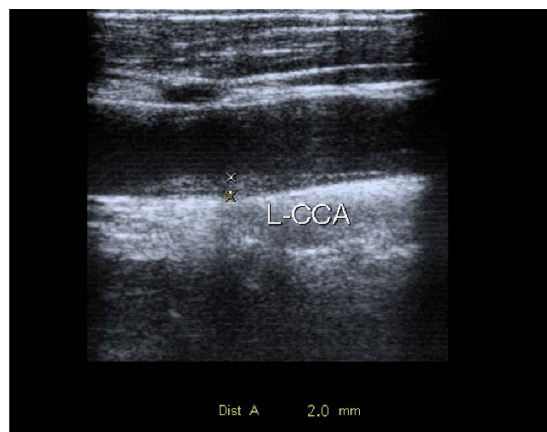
Doppler Echography Result. The marked lesion in the picture highlights the presence of an intimal thickness suggestive of arterial atherosclerosis in the left internal carotid artery.
